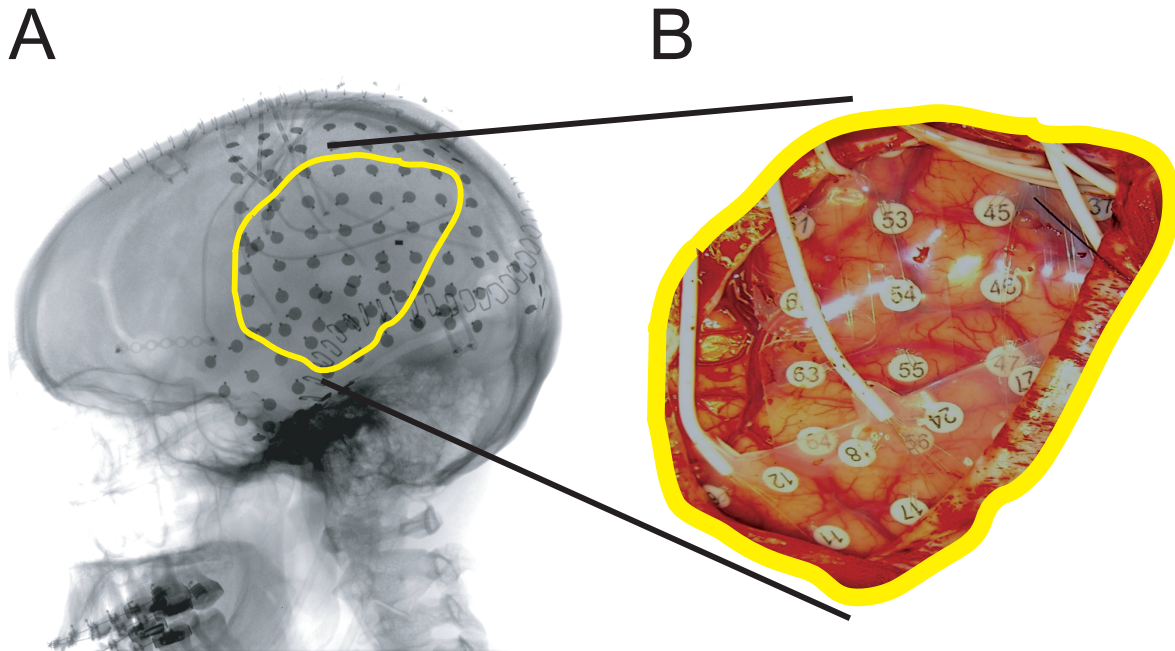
ECoG implant. Example of an implanted subdural grid in Subject B. (A) Lateral radiograph indicating grid position. (B) Subdural grid placed over left frontoparietal and temporal lobes.
